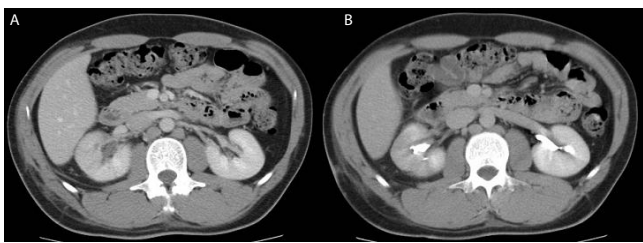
Case 1. CT scan obtained 2 months after renal injury. A) Contrast-enhanced nephrographic-phase helical CT scan shows good uptake of right renal parenchyma. The renal laceration has disappeared. B) Contrast-enhanced excretory-phase CT scan shows good excretion of the right kidney. No contrast extravasation.
